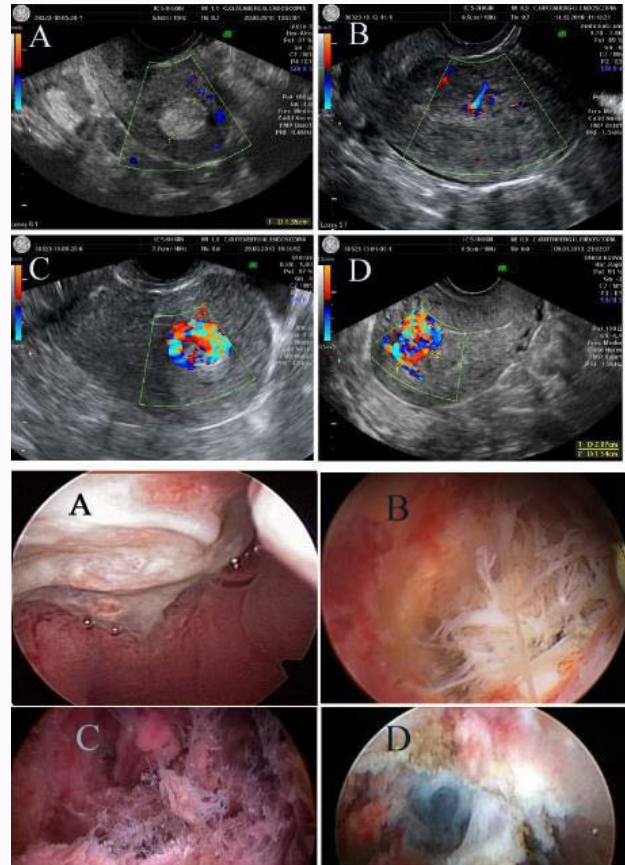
Ultrasonographic and hysteroscopic patterns of RPOC. Gutenberg Classification. A- Type 0: Hyperechogenic avascular mass; white mass with no clear structures. B-Type 1: Different echoes with minimal or no vascularization; well-defined avascular chorionic villi. C- Type 2: Highly vascularized mass confined to the cavity; well vascularized chorionic villi. D- Type 3: Highly vascularized mass with highly vascularized endometrium; aneurism over myometrium in the implantation area [12].
